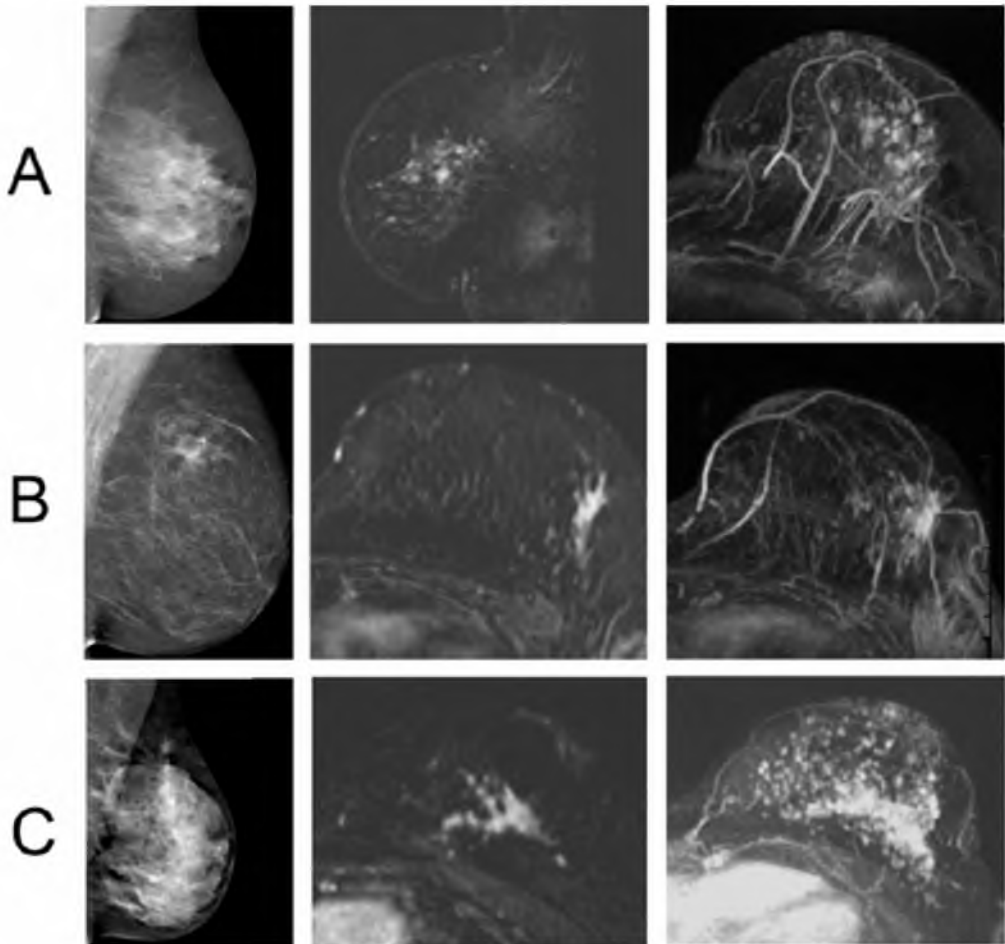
Drie voorbeelden (Rij A, B en C) van aankleurende gebieden zonder massa in de linker mamma van drie verschillende patiënten op respectievelijk mammografie (eerste kolom), subtractive MRI (tweede kolom) en maximale intensiteit projectie van de MRI (derde kolom). De aankleuring was respectievelijk regional (A), segmenteel (B) en diffuus (C). De tumoren bij patiënten A en C waren palpable maar mammografisch occult, de tumor in patient B was op mammografie gedetecteerd, maar de multifocale verspreiding was alleen op MRI zichtbaar.
